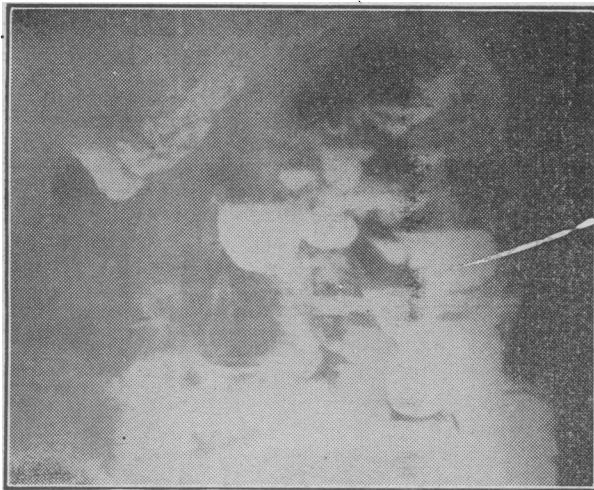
Barium-meal x-ray film in 1951.
